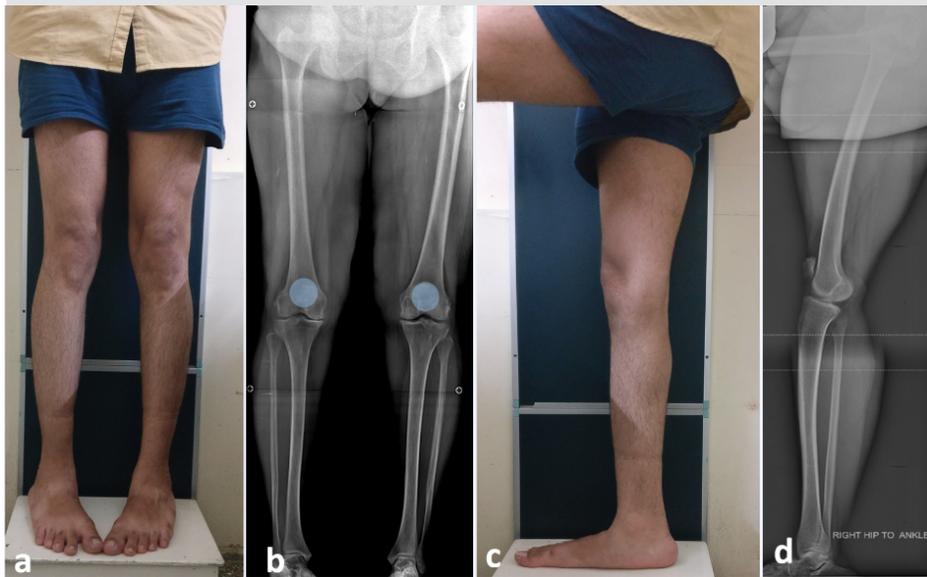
(a) The correct method of positioning a patient for an anteroposterior scanogram. Note that foot is internally rotated about 10-15° so that the patella faces forward. (b) The scanogram thus obtained has the patella centered in the distal femur. (c) The correct patient position for a monopodal stance lateral scanogram with the patient's foot externally rotated about 10-15° and knee maximally extended. (d) The radiograph shows overlapping of the posterior femoral condyles as is required.
